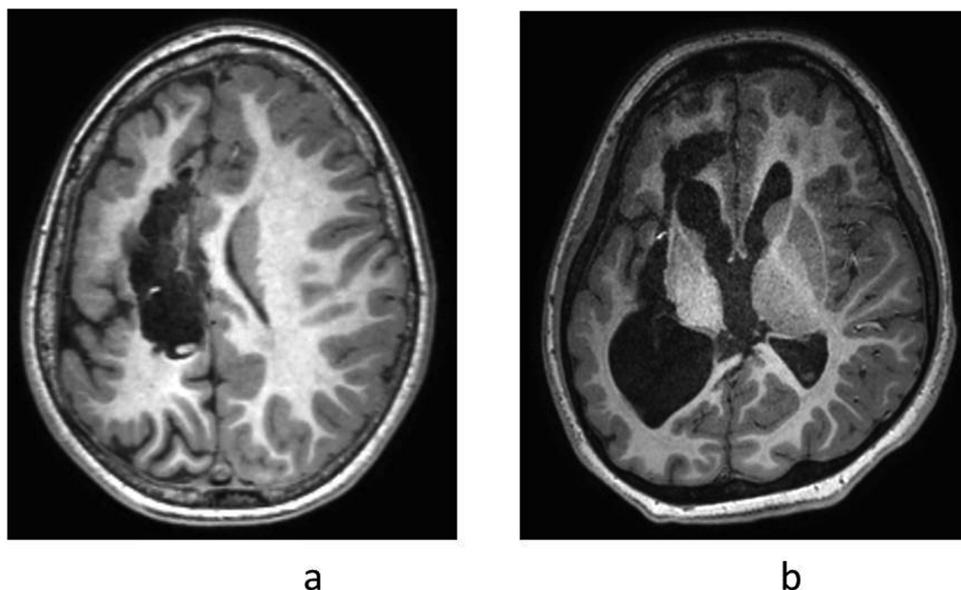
postoperative MRI scan control, T1 weighted sequence in axial view showing peri-thalamic disconnection scar in patient 16 (a) and patient 17 (b).
